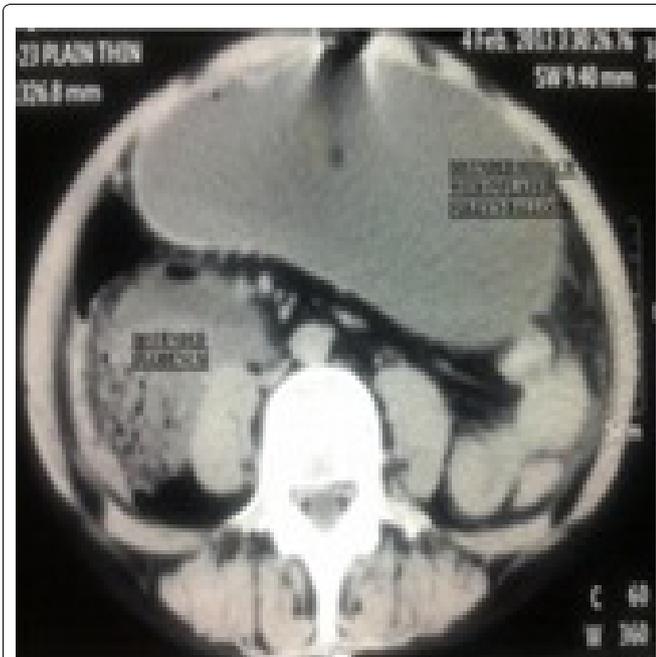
CT abdomen showing distended stomach, duodenum & tip of catheter seen in stomach along with inflated balloon.
